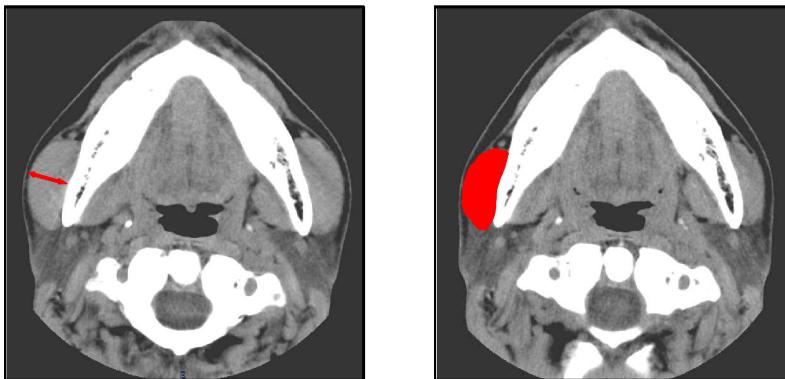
Computed tomographic measurements of the thickness and cross-sectional area of the masseter muscle
